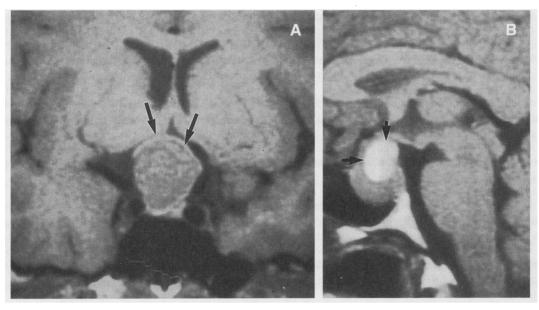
A, The coronal magnetic resonance (MR) image shows a large nonfunctioning pituitary adenoma (arrows) with pronounced suprasellar extension and chiasmal compression. B, A sagittal MR image of another large pituitary adenoma shows spontaneous hemorrhage within the suprasellar portion of the adenoma (arrows). (Photographs courtesy of David Norman, MD.)
